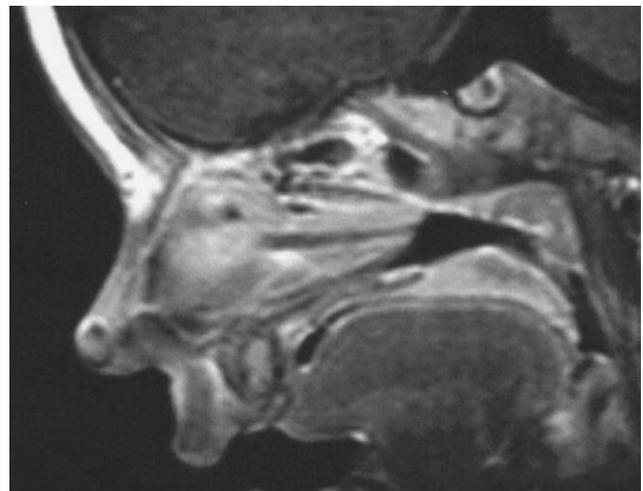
T1-weighted sagittal magnetic resonance image with contrast demonstrates an enhancing round mass at the tip of the nose and an enhancing dermal sinus tract extending intracranially.
